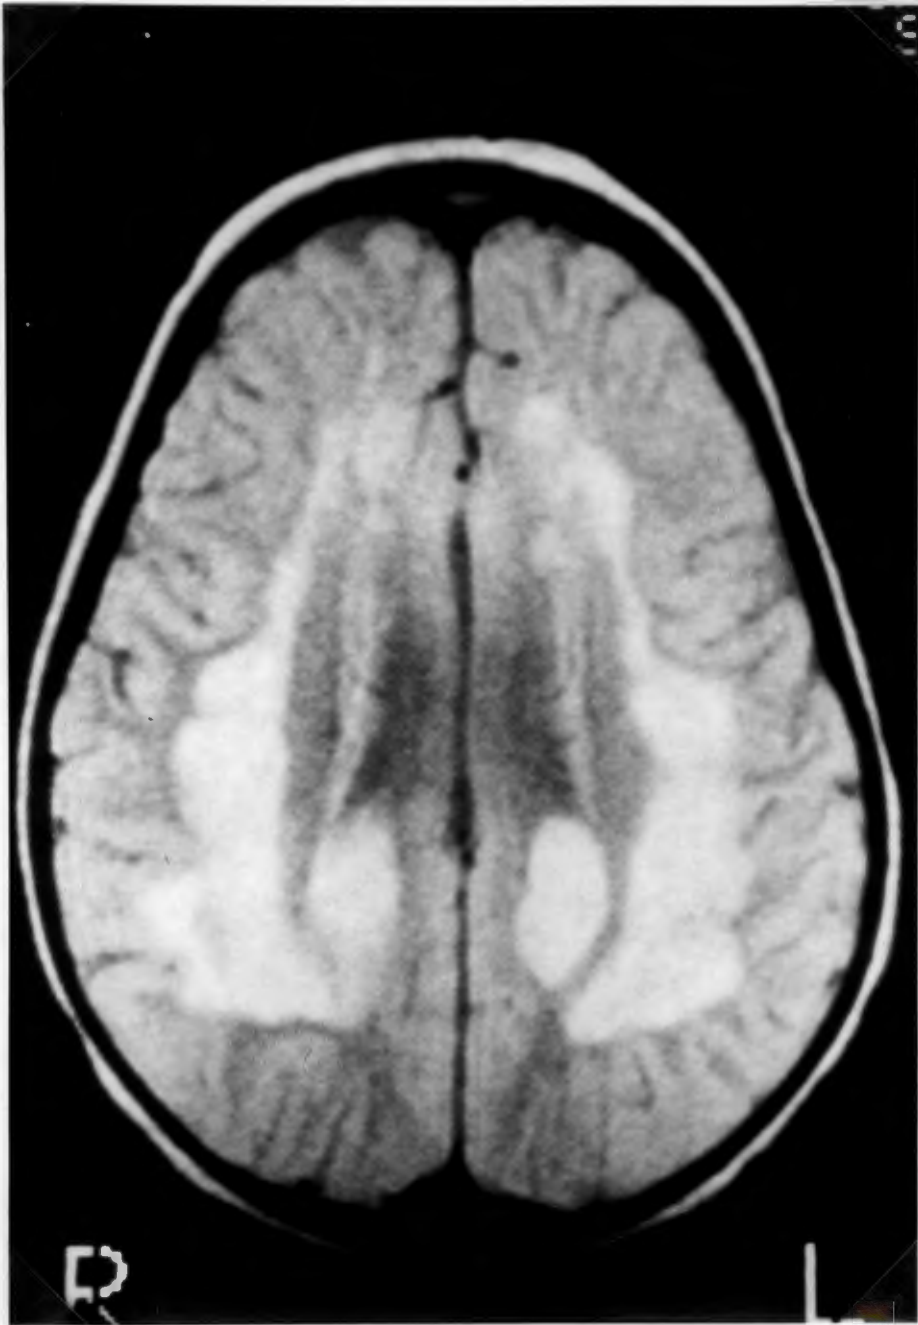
MRI Scan of the cranium of case 22 demonstrates large confluent plaques of demyelination.
